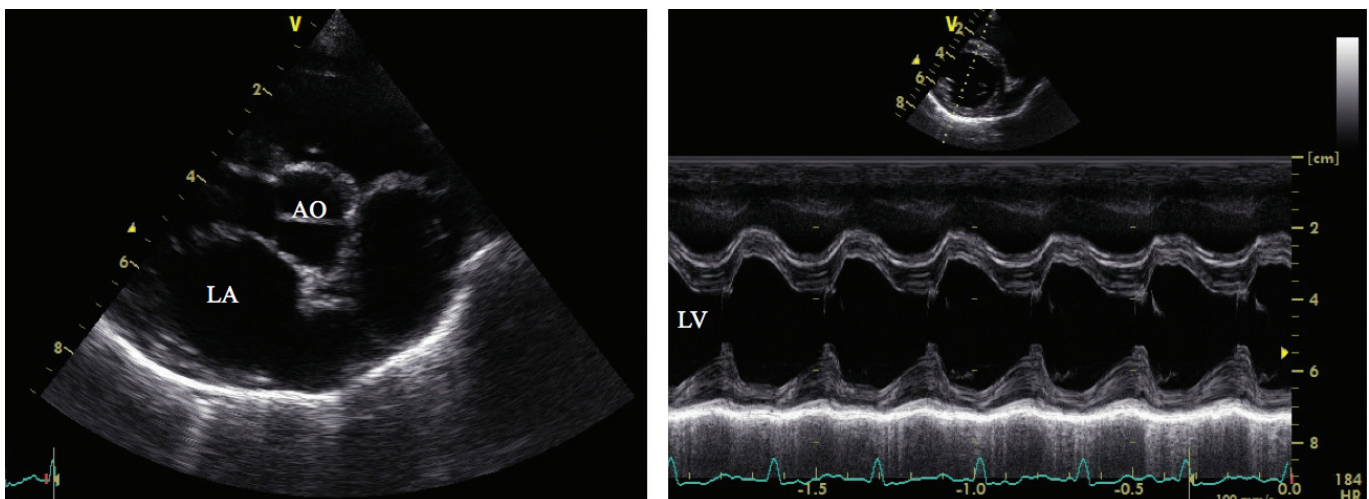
Echocardiographic of transverse image of heart base (left) and M mode image of the left ventricle (right); AO= Aorta, LA = left atrium, and LV = left ventricle.
